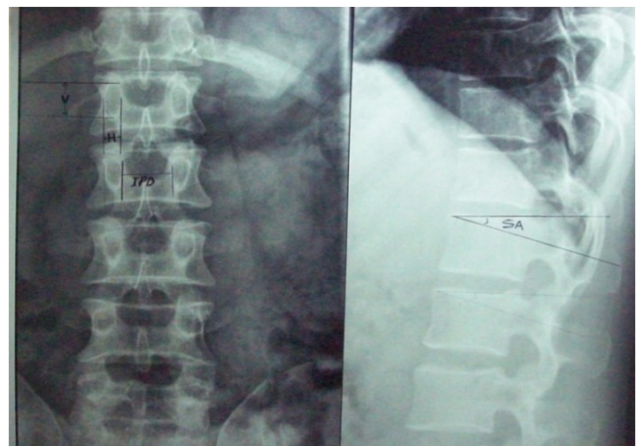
X-ray showing the methods of measurement of pedicle dimensions
